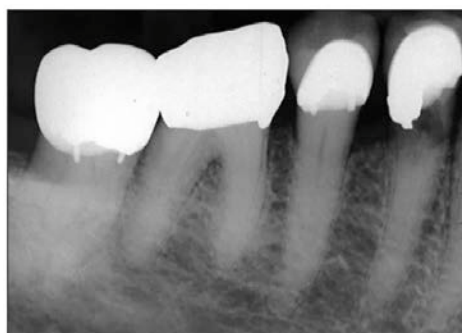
Periapical radiograph showing internal resorption of tooth #28 visible below the restoration.
